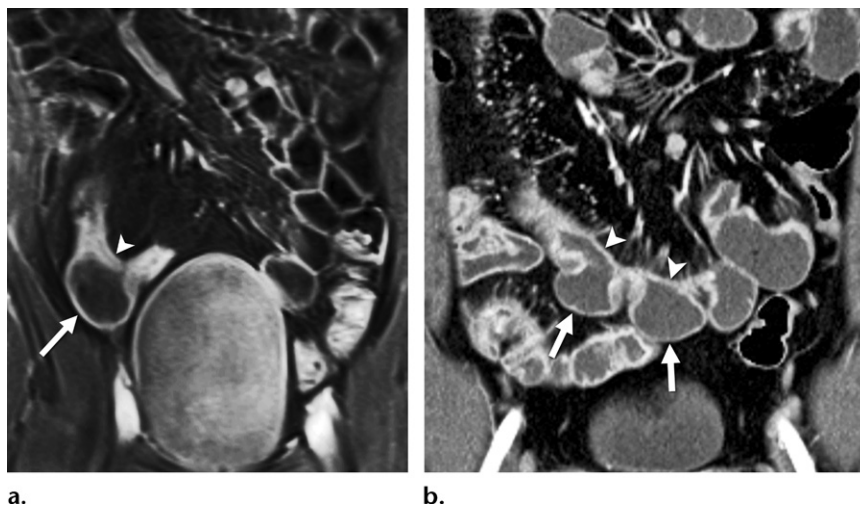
Sacculations in two patients with Crohn disease. (a) Coronal contrast-enhanced fat-suppressed T1-weighted MR enterographic image with biphasic oral contrast material shows asymmetric wall thickening involving the mesenteric wall of a small bowel segment (arrowhead) and a sacculation on the antimesenteric wall (arrow). (b) Coronal contrast-enhanced CT enterographic image with neutral oral contrast material shows several sacculations along the antimesenteric wall (arrows) of a small bowel segment and asymmetric inflammation along the mesenteric wall (arrowheads).
